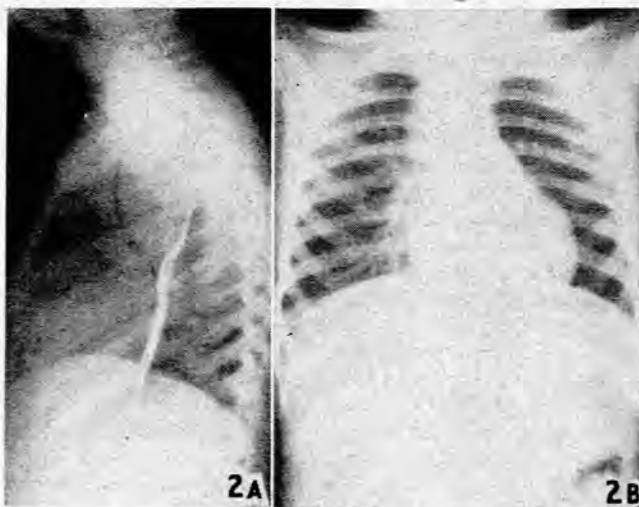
The AP (B) and lateral (A) radiographs in a girl of 4 years, showing a duplication of bronchial origin in a central position between the trachea and oesophagus.
